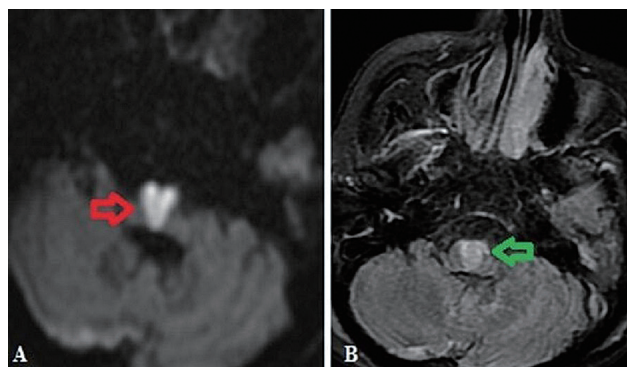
(A) In DWI sequence, bilateral medial medullary area hyperintensity (red arrow) compatible with heart-shaped acute infarct (B) Fluid-attenuated inversion recovery imaging (FLAIR) also showed bilateral MMI resembling a heart (green arrow).
